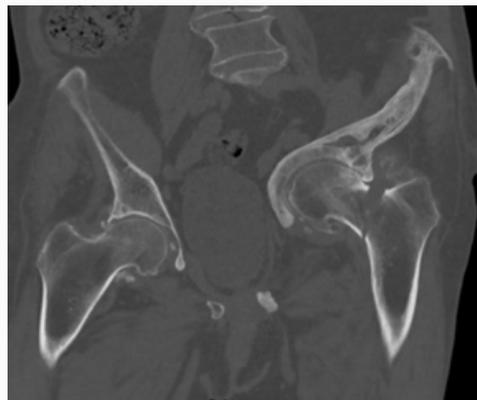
CT scan of the pelvis performed at the emergency department.
